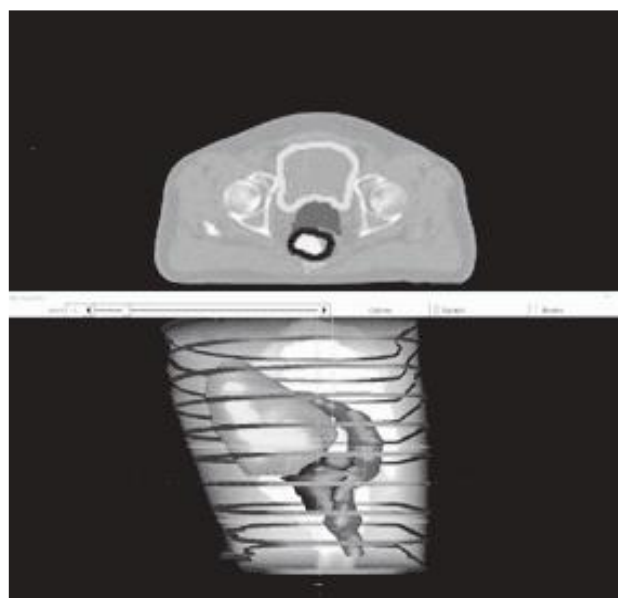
2D view of computed tomography image for prostate cancer patient: the main anatomical structures: bladder, tumor (PTV), rectum.
